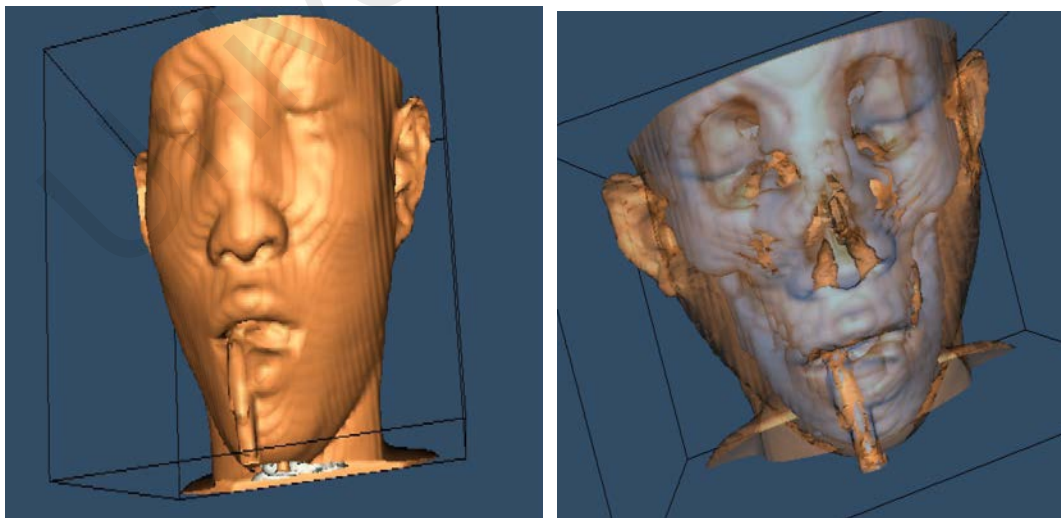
1 3D reconstruction of CT head image
